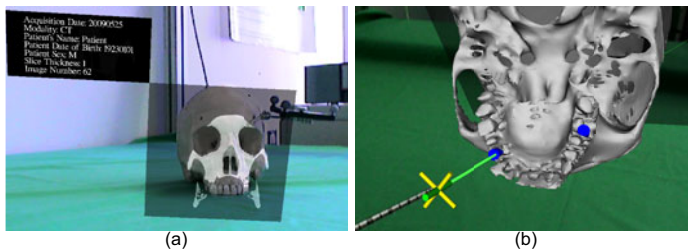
(a) skull model with a CT-image slice, (b) positioning of implant positions represented with blue cylinders
